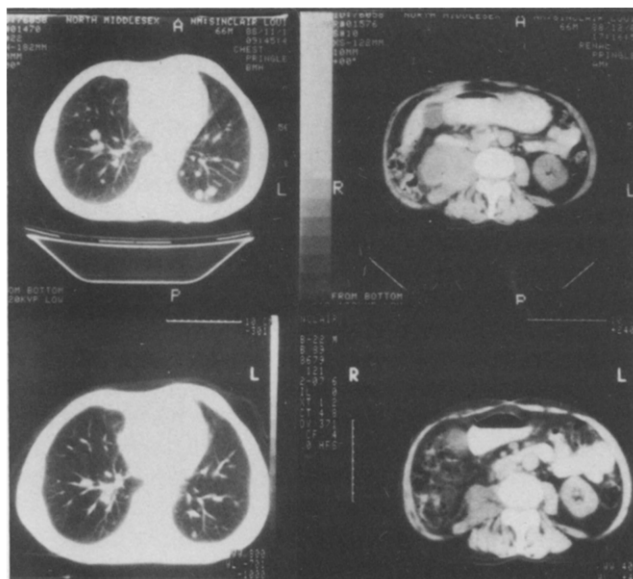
Computed tomography of chest and renal bed in case 13 before and after treatment with IL-2.
